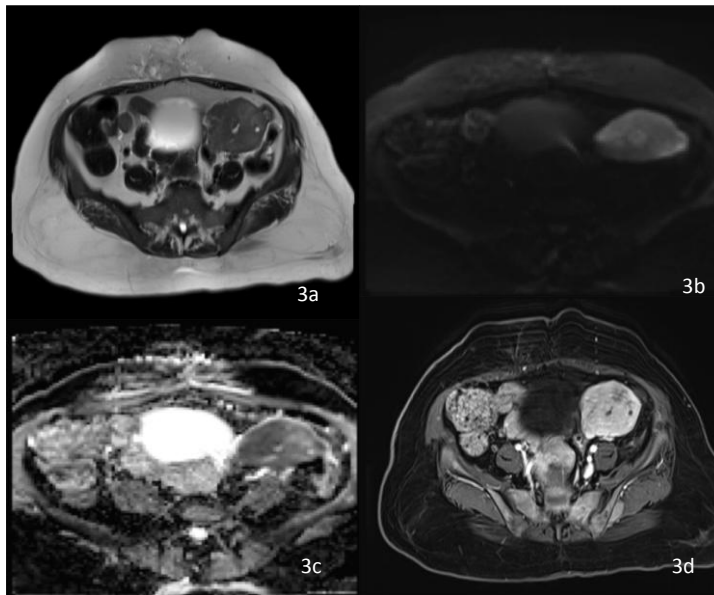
T2 axial image showing mildly hyperintense lesion with few small cystic areas within. Fig 3b, 3c: DWI/ADC image with lesion is showing patchy areas of diffusion restriction Fig 3d: T1 + C Axial image with lesion showing intense homogenous enhancement with few non enhancing areas within.
